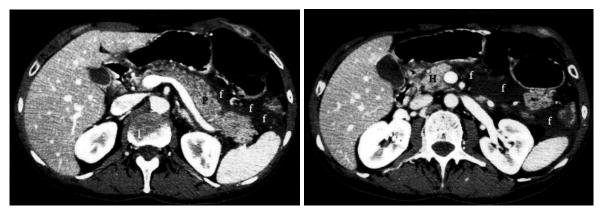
CT of a patient with acute stress pancreatitis.
